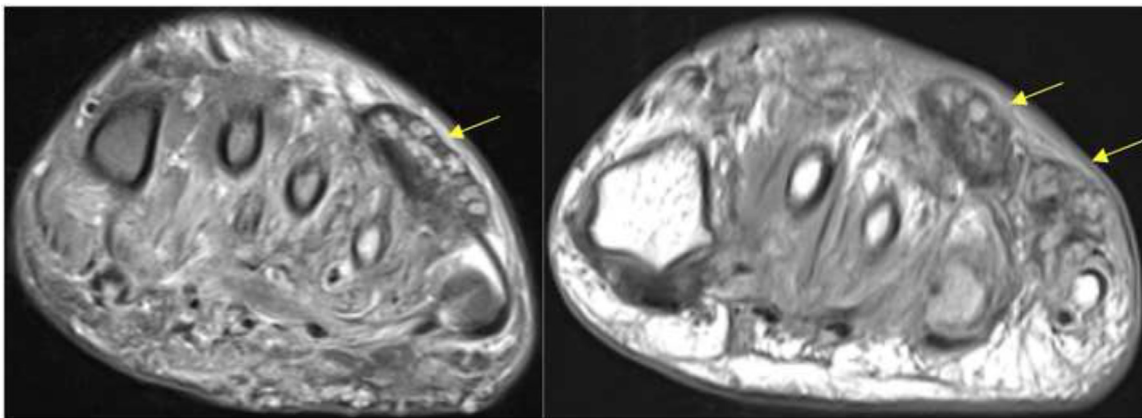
Case 2. Axial MRI sections in proton data (A) and T1 weighting (B), showing multiple round- to oval-shaped iso- to hyperintense lesions involving the subcutaneous tissue of the dorsum of the foot, with peripheral low-signal-intensity fibrosis in between, corresponding to mycetoma grains.
